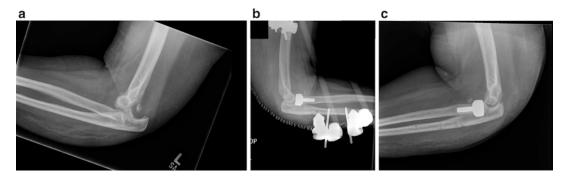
Case demonstrating use of external fixator. (a) Injury film at time of presentation, (b) immediate postoperative radiograph demonstrating use of static external fixator, (c) postoperative radiograph after removal of fixator
